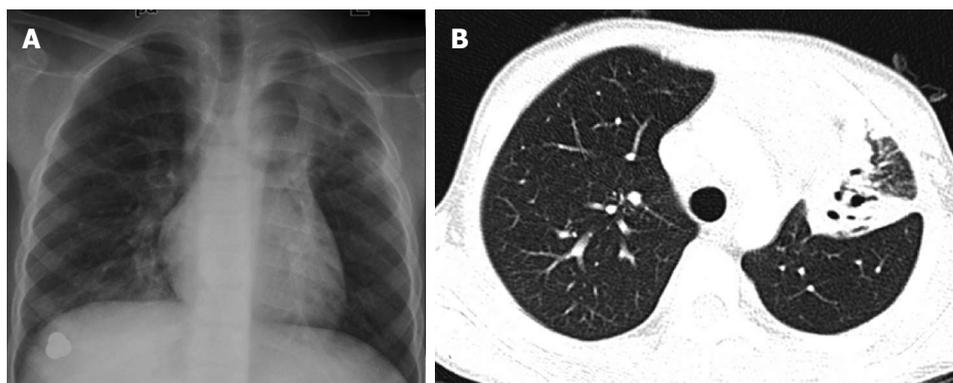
Chest radiograph (A) and axial computed tomography image (B) showing consolidation with cavitation in the left upper lobe.
